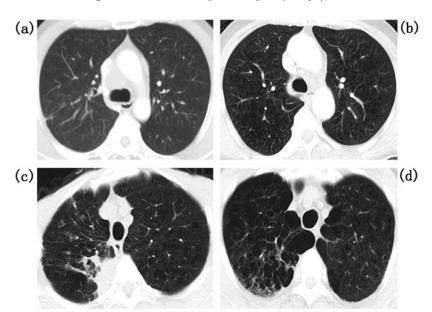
CT Scan of Lungs Showing Early Emphysema
